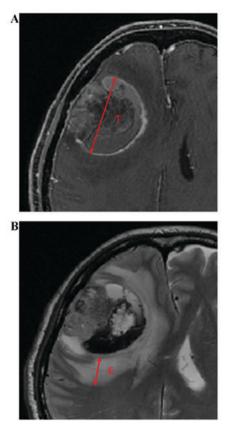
Definition of the E/T ratio. (A) The tumor diameter was measured as the maximum length of tumor on a contrast enhanced T1-weighted image. (B) The extent of edema was measured as the maximum length between the margin of the edema and that of the tumor on T2-weighted image. The E/T ratio was defined as the E/T ratio. E/T, edema/tumor.
